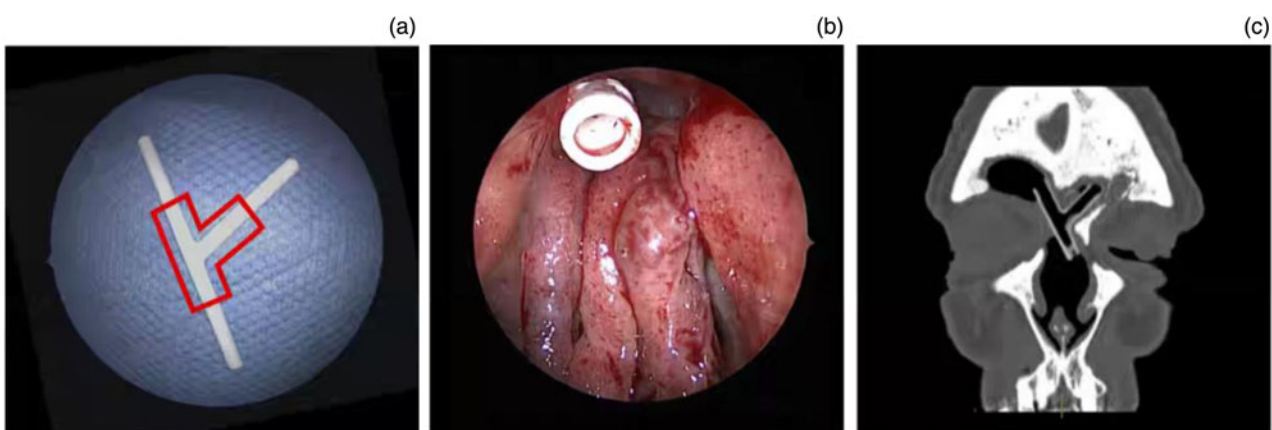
'Y-shaped' paediatric Montgomery T-tube used for Draf III procedures: (a) method of cutting the stent (indicated by the red lines); (b) endoscopic appearance; and (c) radiological computed tomography appearance in the coronal plane.
